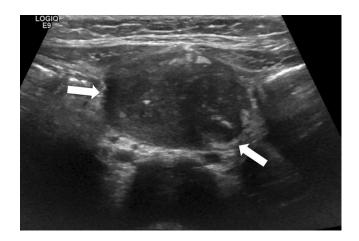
Transverse ultrasound image superior to the bladder in a patient with clinical concern for umbilicus/abdominal wall cellulitis shows an elongated heterogeneous lesion (*arrows*) in the midline extending from the dome of the bladder to the umbilicus, compatible with inflammatory changes related to an underlying urachal remnant.
